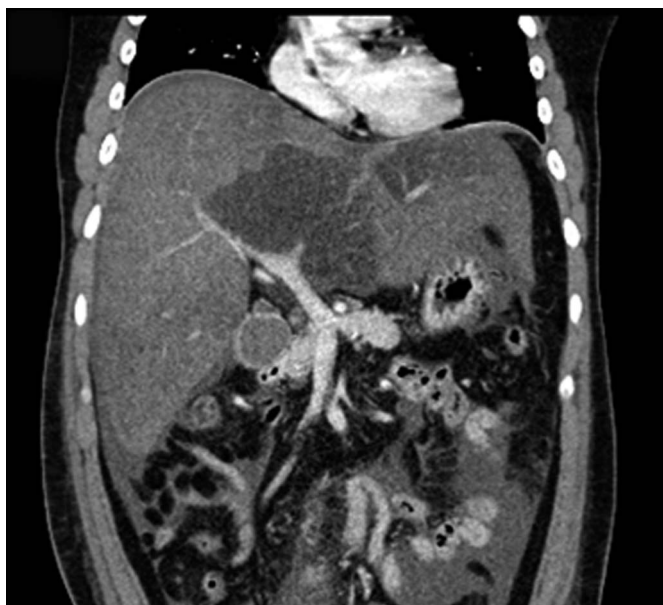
Abdominal computed tomography at admission showing hepatomegaly.
